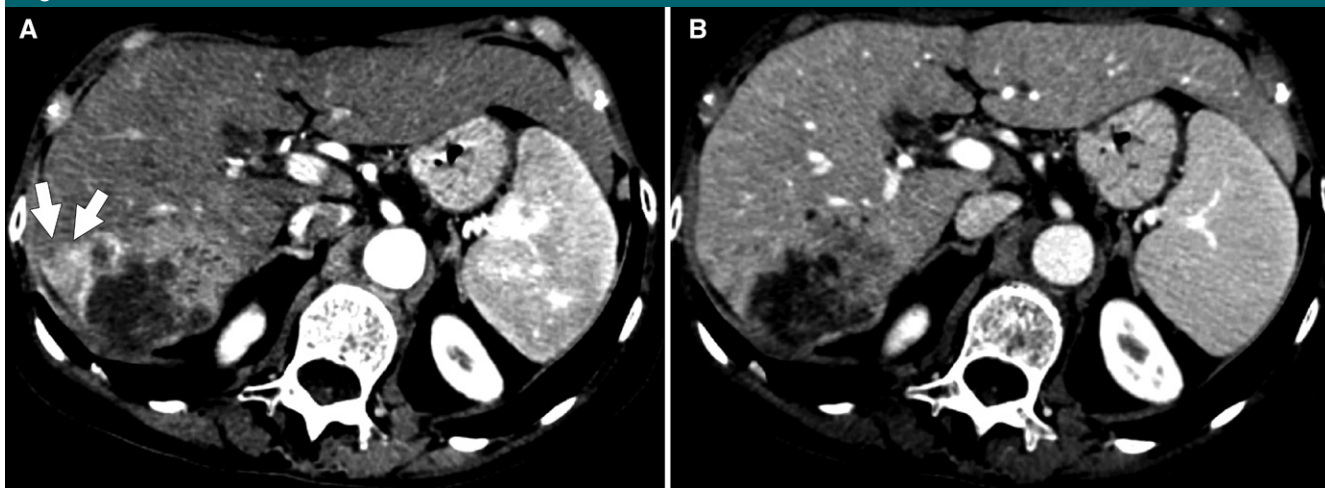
Axial CT images show peritumoral enhancement. *A*, External portion enhancing in the arterial phase in the lateral aspect (arrows), *B*, appears isoattenuating when compared with the background parenchyma in the equilibrium phase.
